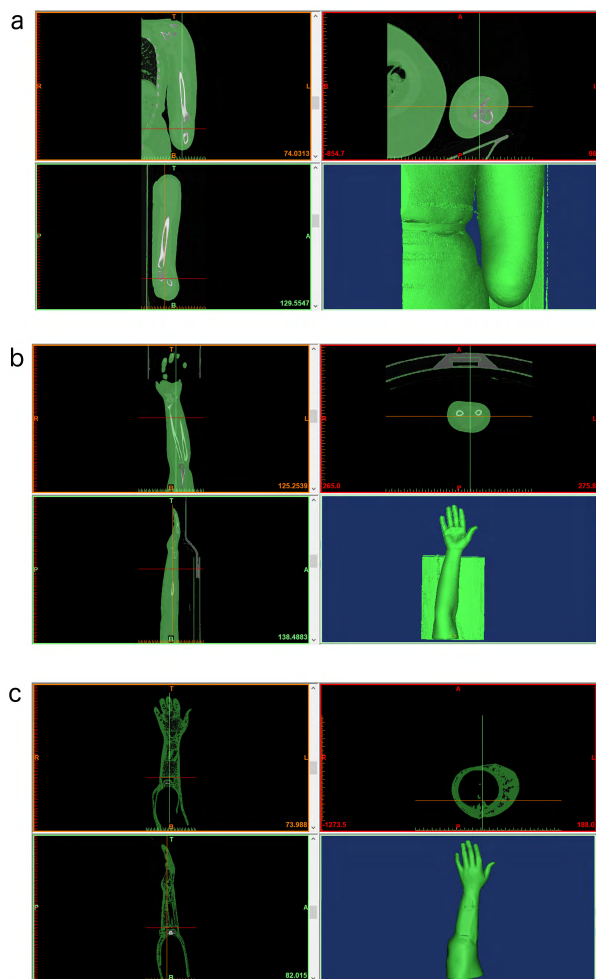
Computer Tomography (CT) images. (a) Amputated left arm. (b) Uninjured right arm. (c) Prosthetic arm. Each set of data are visualized according to the following views: coronal or the front view (top left); axial or the top-to-bottom view (top right); sagittal or the right side view (bottom left) and 3D model reconstruction (bottom right).
